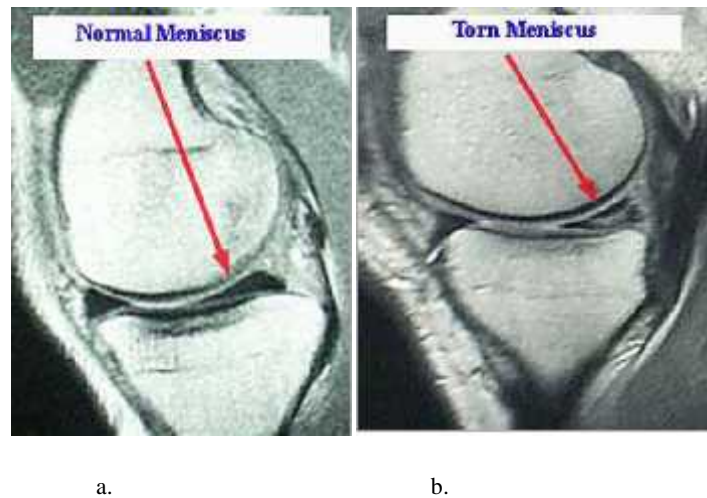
Magnetic resonance imaging scan showing a normal meniscus & torn meniscus.
